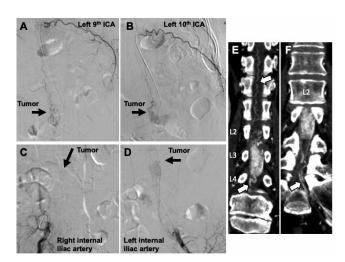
Preoperative angiography (A-D) and post-contrast CT images (E, F). Tumor was indicated by black arrows (A-D). Tumor feeders arose from the left 9th and 10th intercostal arteries (ICAs) (A, B) and the internal iliac artery on both sides (C, D). Spinal arteries were followed by the left 9th and 10th ICAs. Strong enhancement of the tumor by contrast media were shown from left 10th ICA and left internal iliac artery. CT angiography showed feeder arteries (E, F) and a draining vain (F), which were indicated by white arrows.
